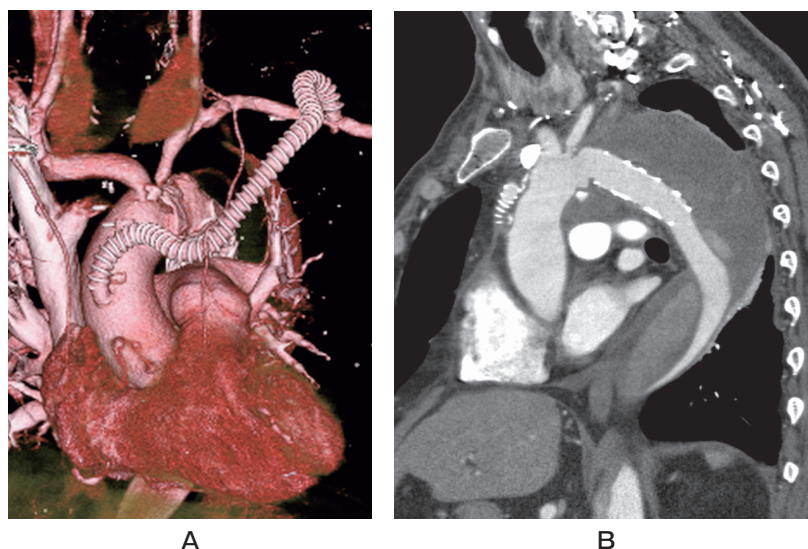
CT angiogram after the frozen elephant trunk repair and left subclavian artery debranching. A, Extra-anatomical debranching from the ascending aorta to the left axillary artery; B, Incomplete thrombosis of the thoracic false lumen was revealed after the entry closure of the Stanford type B aortic dissection.
